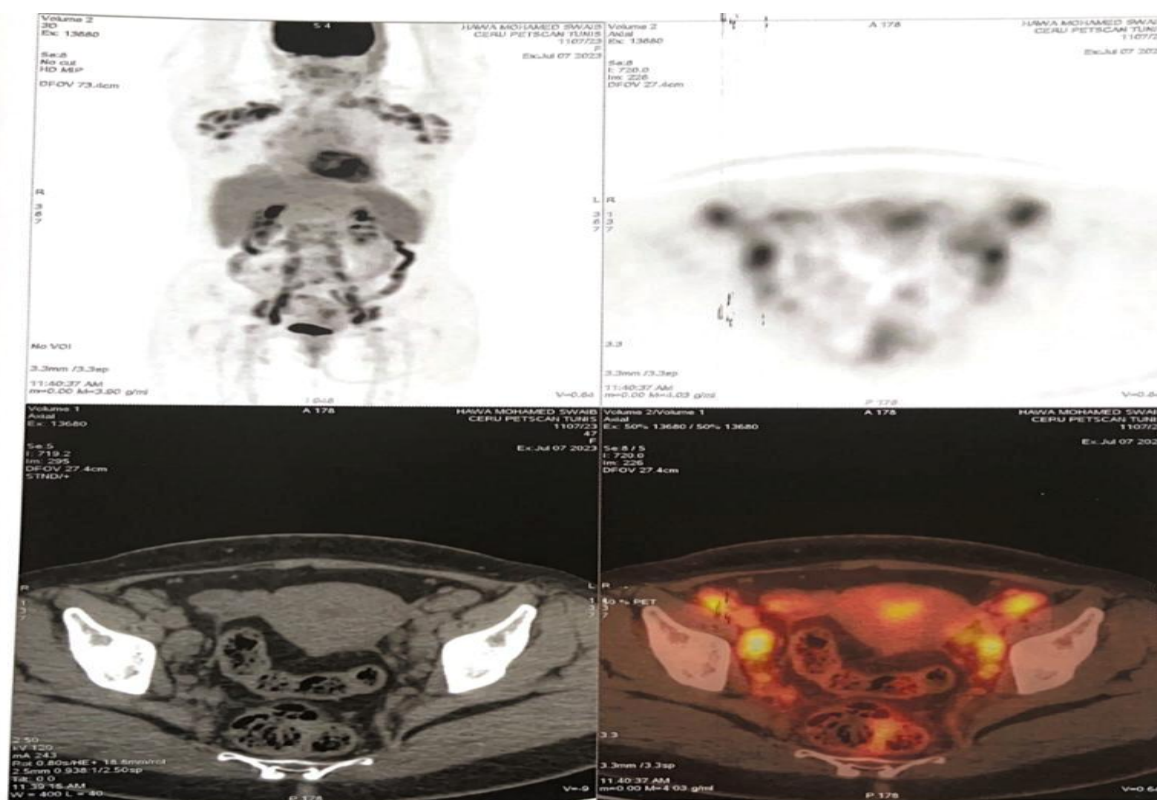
Initial PET-CT scan (Coronal and Axial views) showing intense FDG uptake in the pelvic and abdominal regions, indicating active lymphadenopathy.
